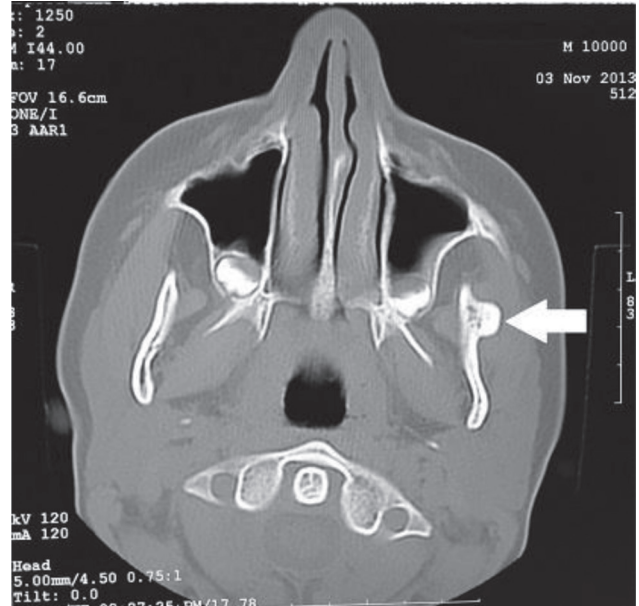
CT scan showing 0.8 cm osteoma originating from the left zygomatic bone.
